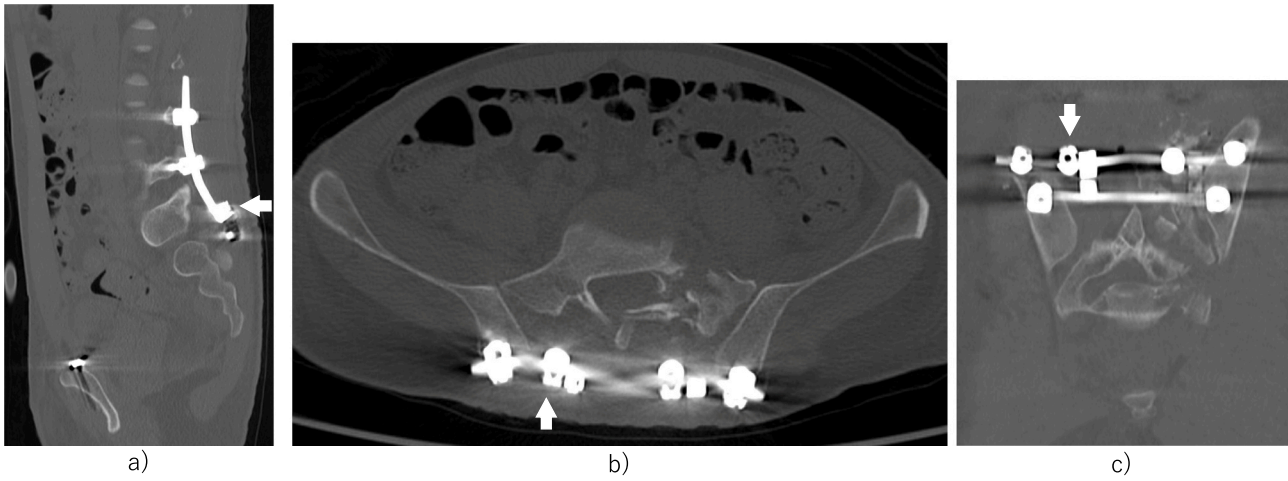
(a) One week after obtaining operative sagittal CT image.
